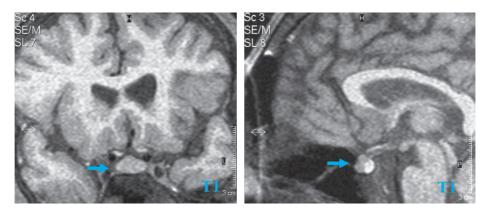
Pituitary Gd enhance MRI (Case 1)
